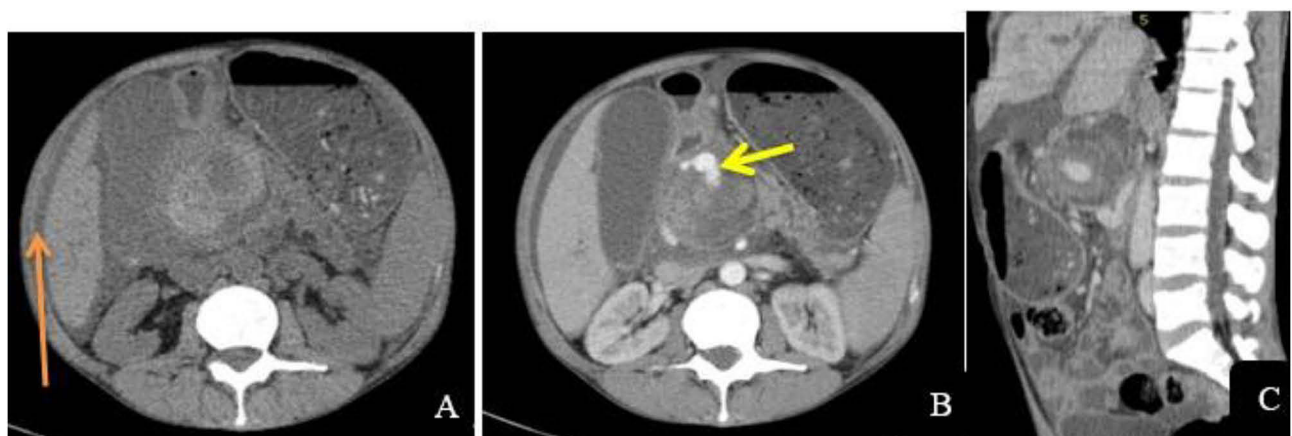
(A) Non-contrast CT axial, (B, C) contrast-enhanced axial and sagittal images show a 6 cm cystic lesion in the pancreatic head with an enhancing intralésional focus (yellow arrow) isodense to the aorta; suggestive of a pseudoaneurysm. Small ascites (Orange arrow in A).
